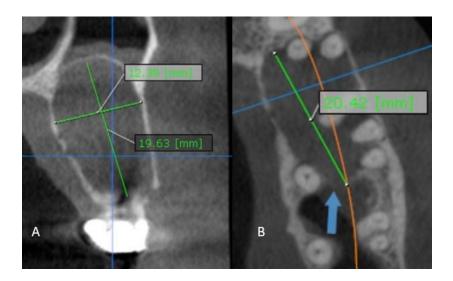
Cone beam computed tomography, measurement of the lesion size: bucco-palatinal diameter (A)and antero-posterior diameter (B)
